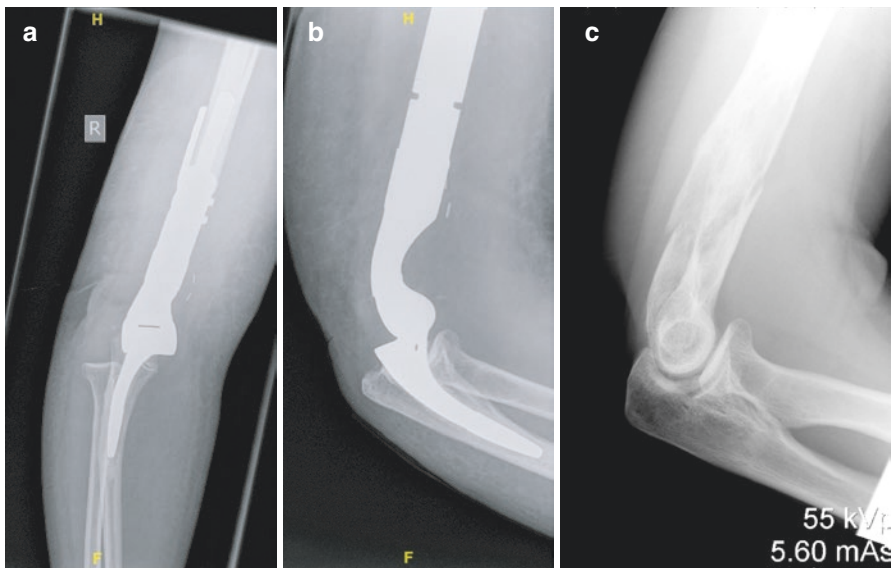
(a) Anteroposterior and (b) lateral plain radiographs of a distal humeral tumour endoprosthesis following resection of (c) a distal humeral tumour
